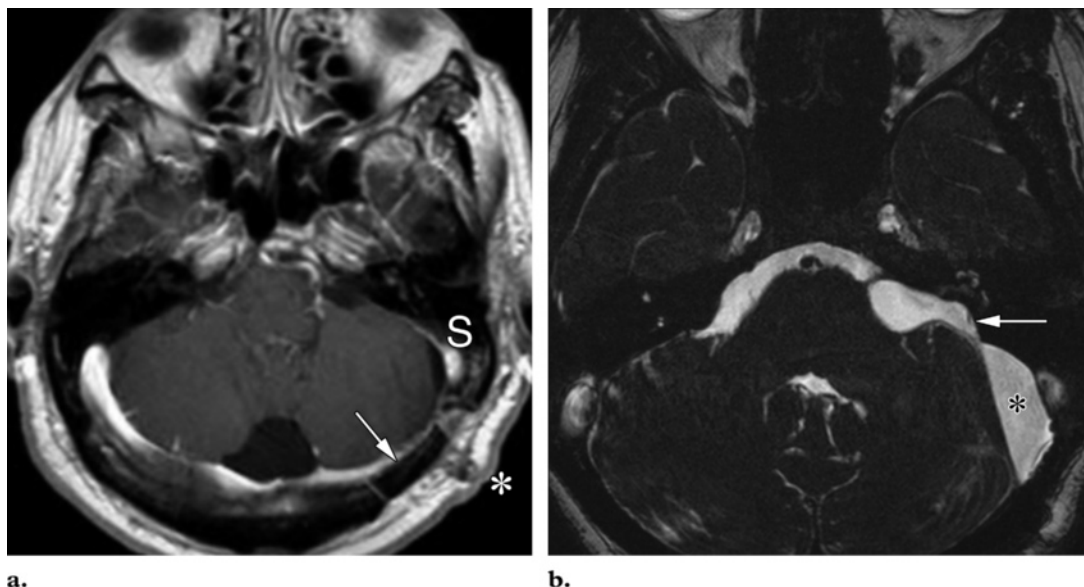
Suboccipital approach. (a) Axial contrast-enhanced fat-suppressed T1-weighted MR image shows suboccipital resection changes, including a craniotomy defect (arrow) behind the sigmoid sinus (S) and a postauricular scar (*). (b) Axial 3D T2-weighted SPACE image shows absence of the posterior IAC wall (arrow), which is inherent in the suboccipital technique. An extraaxial fluid collection (*) is often present and exerts a variable mass effect on the cerebellum.
